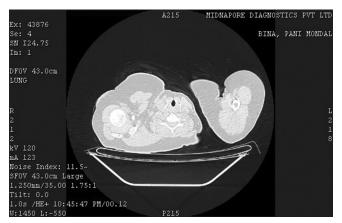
CT findings with D-Dimer <1.4
